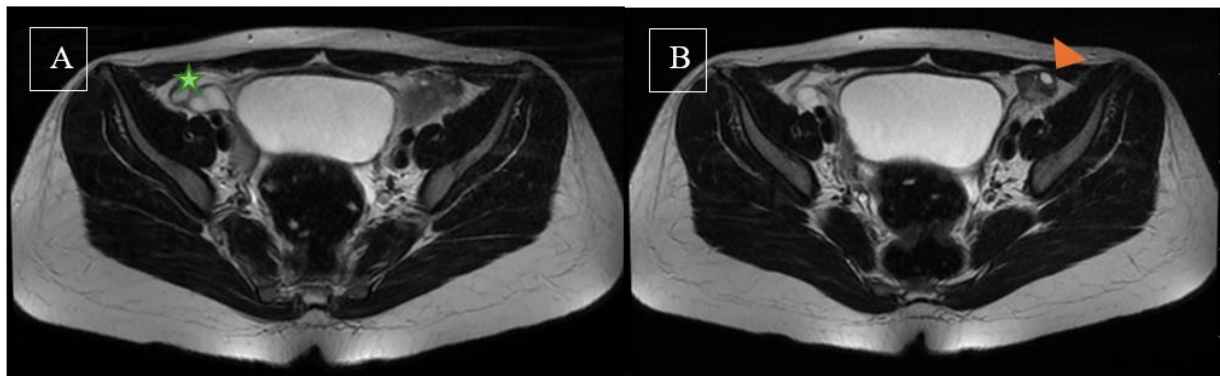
(A, B) Axial T2-weighted MRI images from Case 2 showing the right ovary (asterisk) in (A) and the left ovary (arrowhead) in (B). Both ovaries appear normal in signal and morphology
